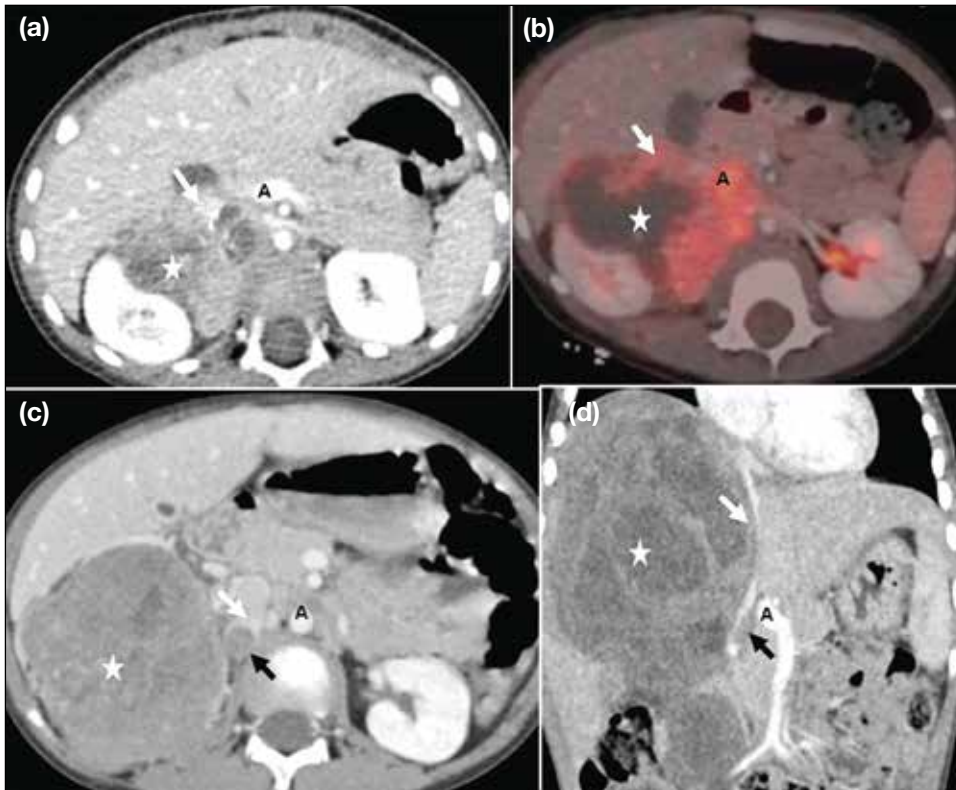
(a) Axial contrast-enhanced computed tomography (CECT) and corresponding (b) positron emission tomography/computed tomography fusion images of a 5-year-old child with neuroblastoma of the right adrenal gland show a hypermetabolic enhancing lesion with non-enhancing necrotic areas in the right suprarenal region (stars), encasing and infiltrating the inferior vena cava (IVC) [white arrows]. (c) Axial and (d) coronal CECT images of the abdomen of a 7-year-old child with Wilms tumour of the right kidney show a large heterogeneously enhancing tumour in the right kidney (stars), with tumour thrombus in the right renal vein (black arrows). The lesion also compresses the right lobe of the liver and causes extraluminal compression of the IVC (white arrows). Abbreviation: A = aorta.
